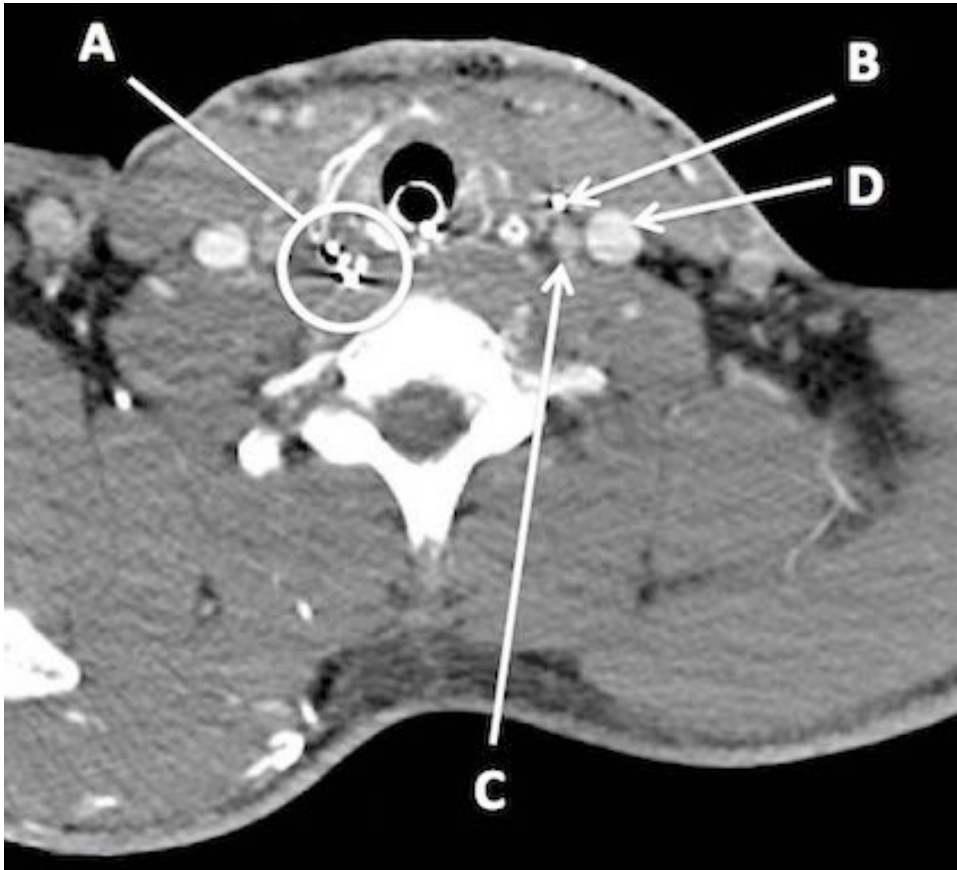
Axial CT angiogram at the level of C4 from a UK serviceman injured by an improvised explosive device. Multiple small fragments are seen on the right side of the neck (A). A fragment (B) lies adjacent to the carotid artery (C) and internal jugular vein (D).
